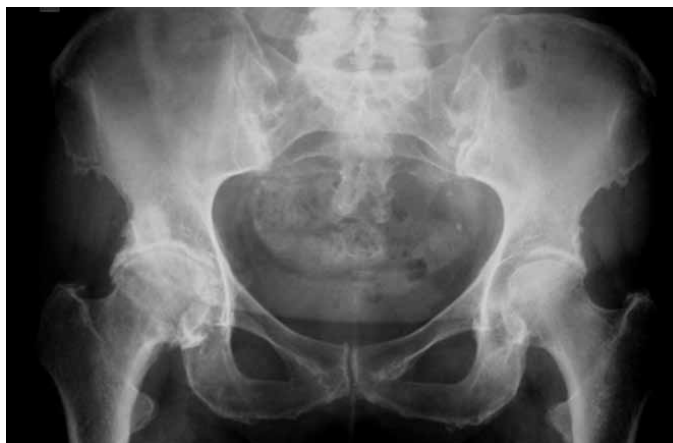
AP radiograph showing arthrosis in the right femoral coxa.
